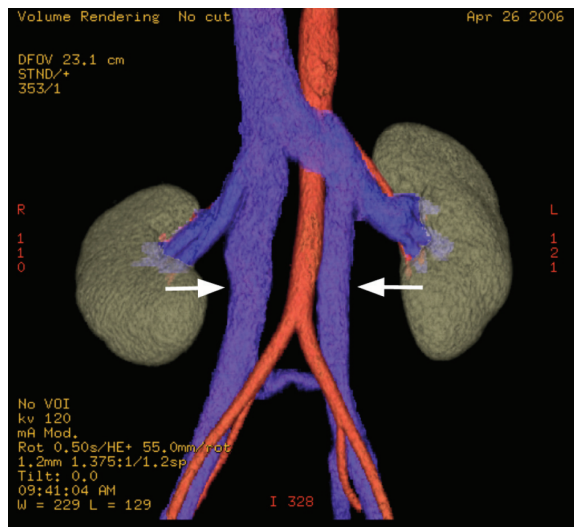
27-year-old female renal donor with duplicated inferior vena cava (IVC). 3-D volume-rendered CTA image demonstrates two IVC (white arrows) joining together at left renal venous level
